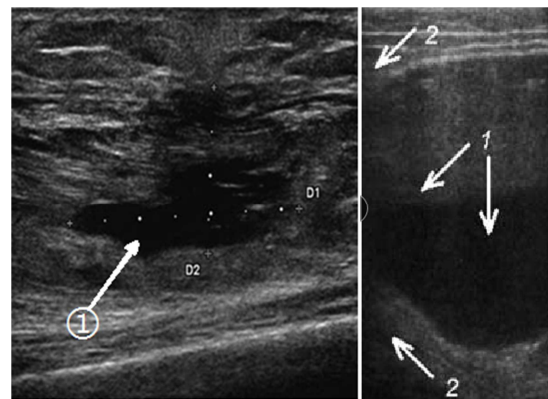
Intermuscular hematoma of the quadriceps muscle of the right thigh. Ultrasound examination of the amputation stump of the thigh. Hematoma. 1 - hematoma, 2 - muscle tissue.
